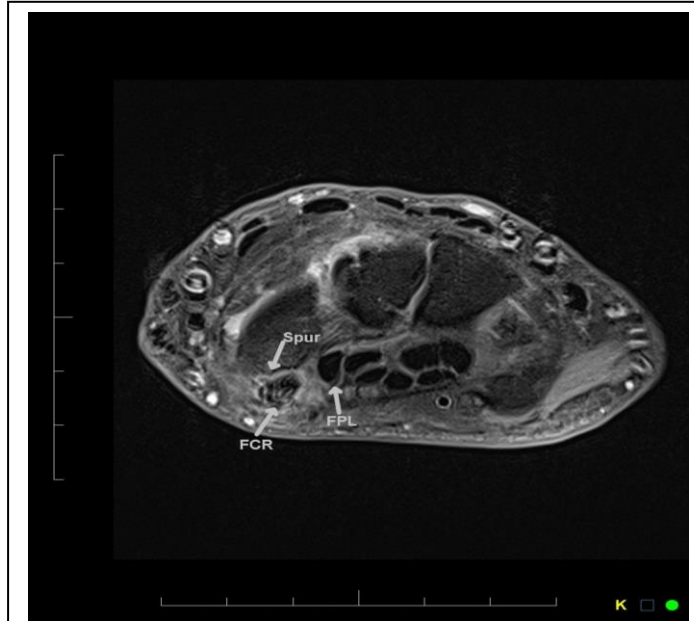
MRI image (Proton Dense with fat saturation) of wrist, at the level of scaphoid spur before diving deep to 2nd metacarpal insertion, FCR is grossly thickened with multiple interstitial high signals (“marbelling effect”) and peritendon oedema, suggesting tendinitis with intra substance tears.(compare with normal black FPL, flexor pollicis longus tendon).
